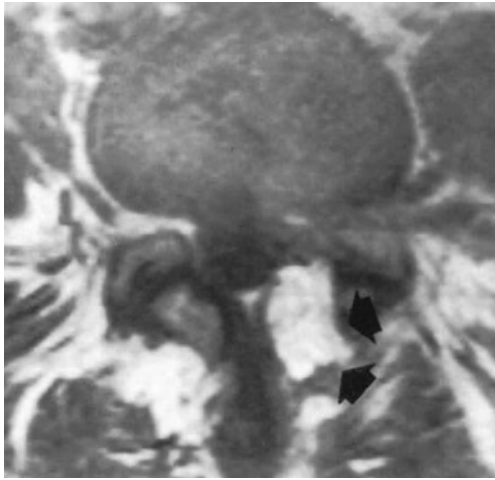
Spin-echo T1-weighted axial MR image showing a fat graft (arrows) in the site of laminotomy.
